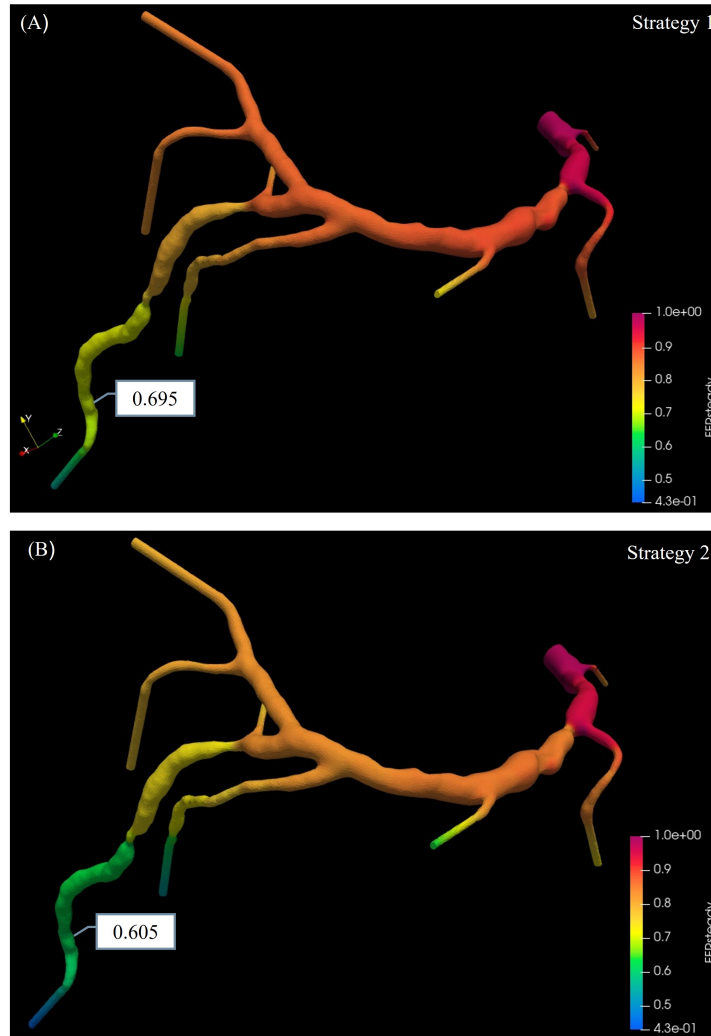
Comparison between the  $FFR_{CT}$  map obtained using the first (A) and the second approach (B) for estimating inlet coronary flow-rate.
